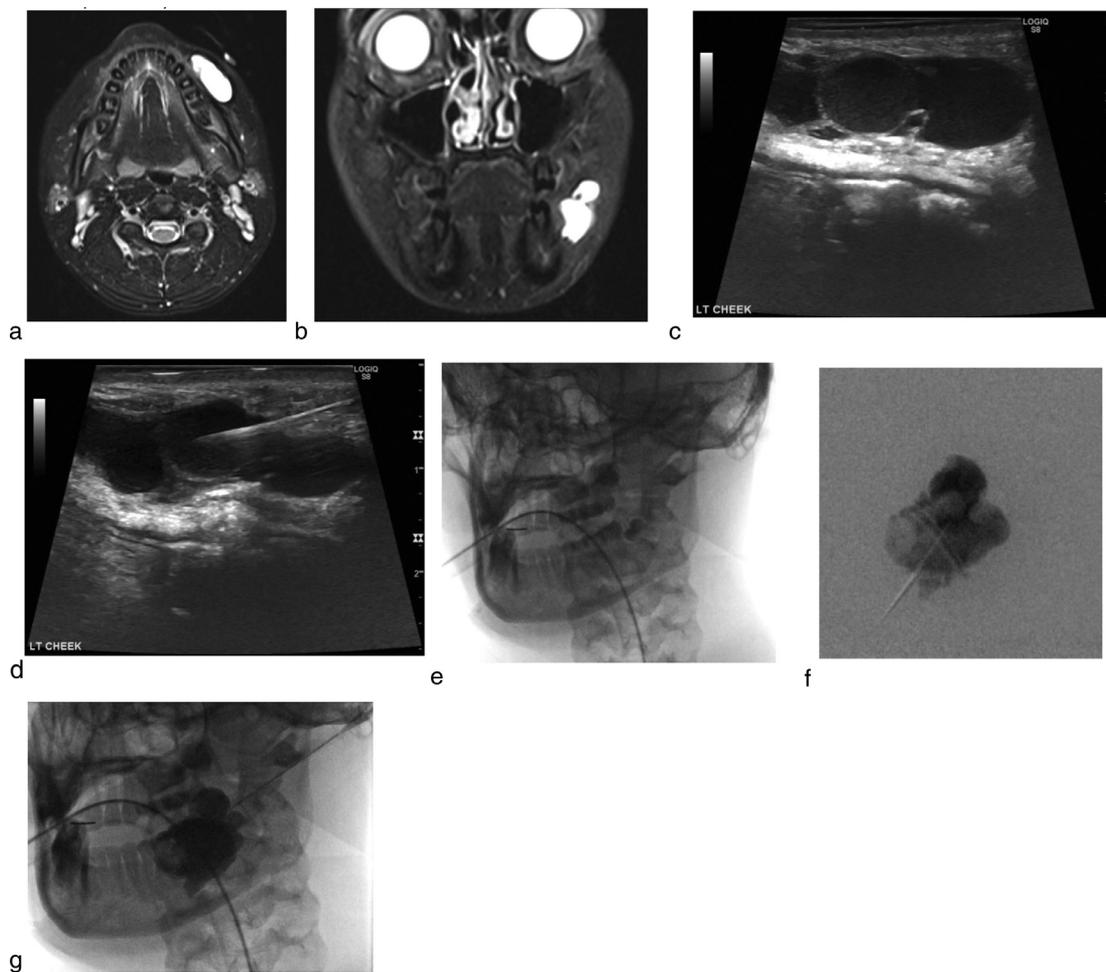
14-year-old female with macrocystic LM of the left cheek overlying the mandible. Sclerotherapy was performed with doxycycline. Axial T2 fat-sat (a) and coronal STIR (b) magnetic resonance images show multicystic lesion in the left cheek compatible with macrocystic LM. Grayscale ultrasound images show multiple superficial macrocysts (c) and ultrasound-guided placement of a 21-gauge EchoTip needle into the lesion (d). Scout fluoroscopic image prior to sclerotherapy (e) was obtained. Intralesional injection of contrast using negative roadmap fluoroscopic technique (f) demonstrates filling of the macrocysts without evidence of extravasation. Postsclerotherapy spot fluoroscopic image (g) shows opacification of multiple macrocysts in the left cheek.
